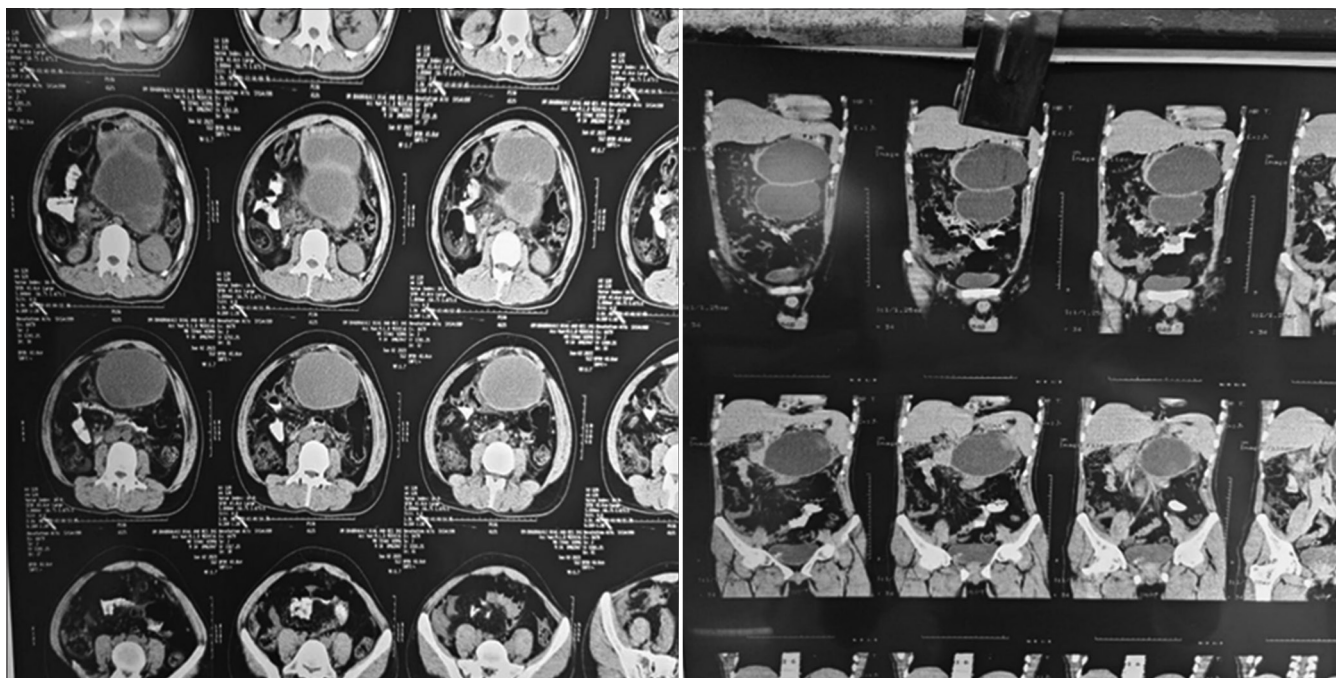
Computed tomography abdomen images suggestive of double mature pseudocysts of pancreas with no communication between the two cysts
